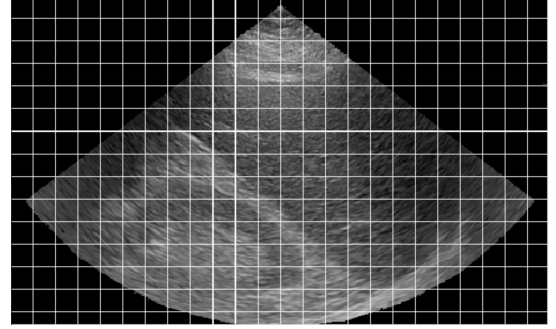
Example of window division in ultrasound image. Window Size: 25x25 pixels.
